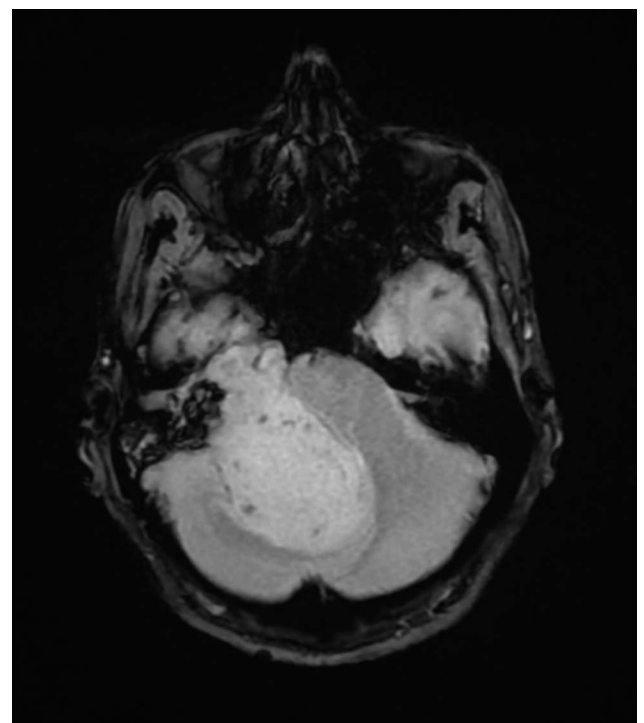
Cerebral MRI in axial section with T2-weighted sequence showing an extra-axial expansive process in iso and hypersignal.
